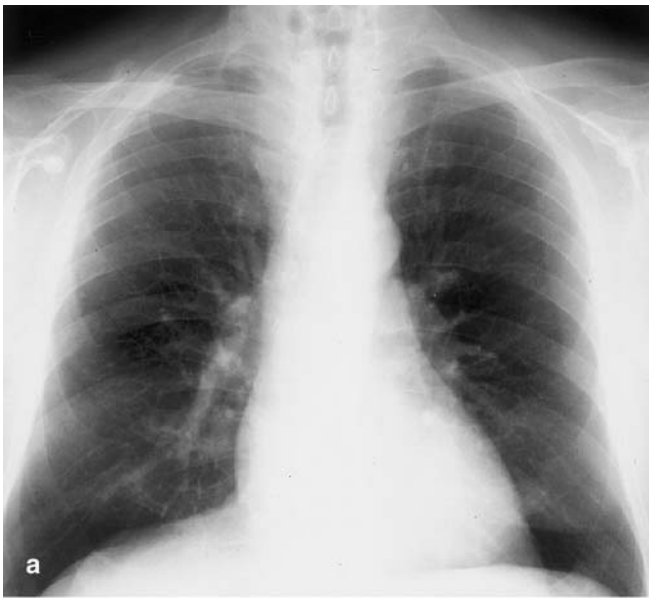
Acute PE in an 80-year-old man. a Frontal chest X-ray is normal b Coronal reconstruction image obtained with multislice CT (soft-tissue window settings, 1.3 mm collimation, 0.6 mm interval reconstruction) reveals multiple emboli located in the left inferior artery (*arrowhead*) and laterobasal artery (*straight ar-*
